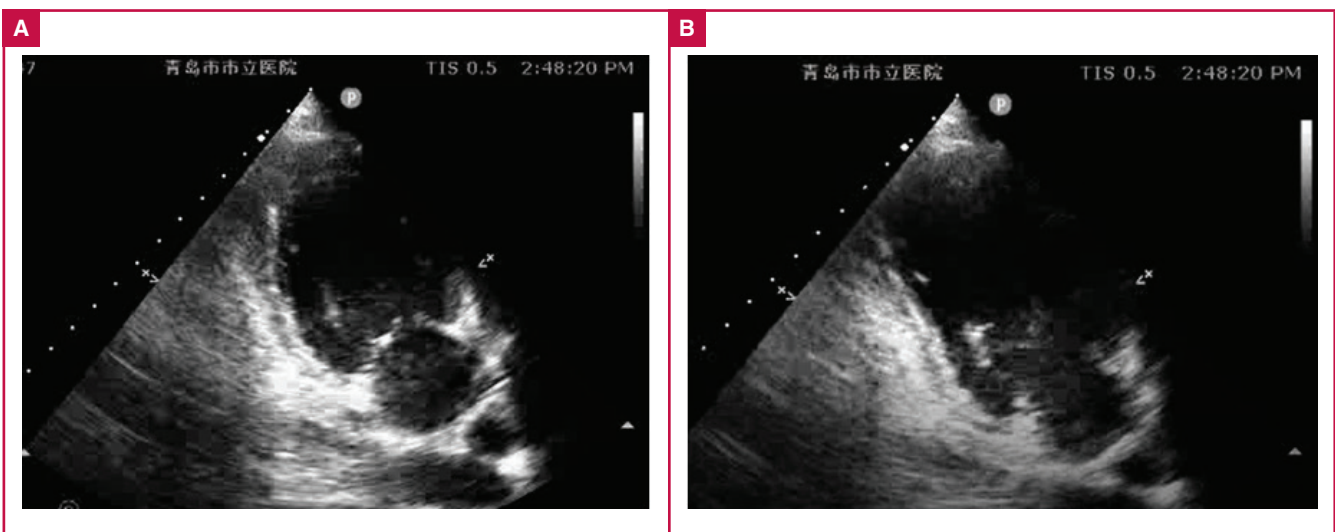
Transthoracic echocardiogram (TTE) showing severely impaired left ventricular systolic function with akinesis/hypokinesis of the basal and middle left ventricular segments and hyperkinesis of the apical segments. A. Systolic phase. B. Diastolic phase.
